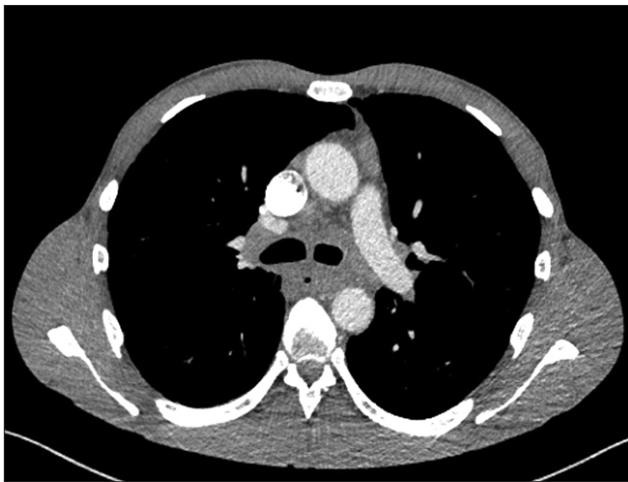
Computed tomography scan showing mediastinitis.
